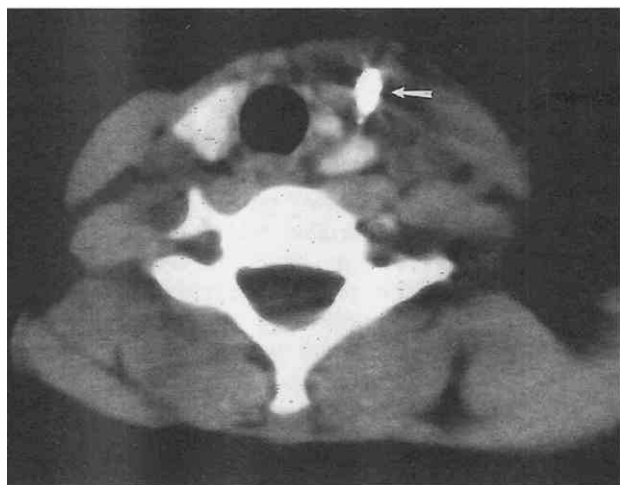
Fourth branchial apparatus sinus. Axial noncontrast CT after the patient had ingested oral contrast medium. Barium is present in a sinus tract (arrow) that lies anterior to the thyroid gland on the left. The tract arose from the piriform sinus and continued into the mediastinum.
